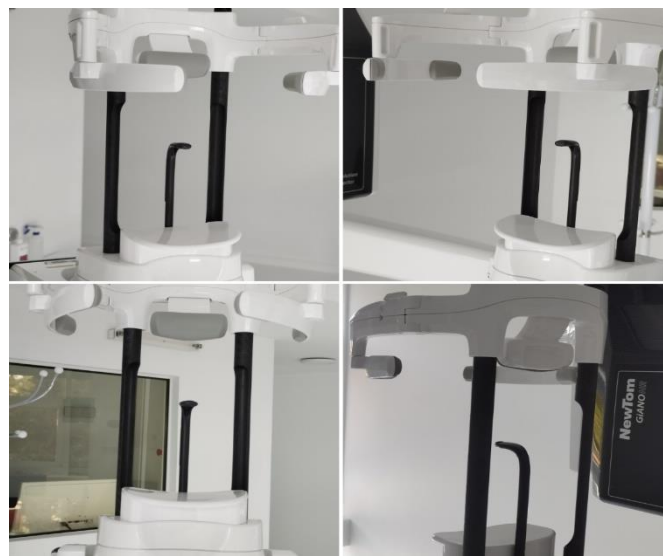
Chin Rest, Head Support, and Bite Block on the Cone-Beam Computed Tomography Scanner.
